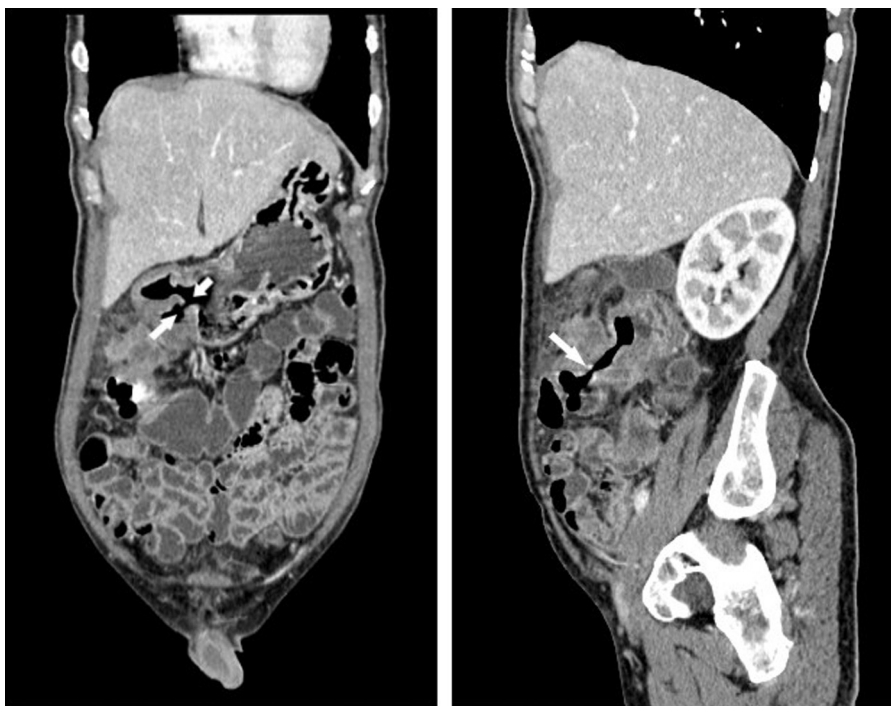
Preoperative Sagittal and Coronal CT scan revealing gastrocolic fistula demonstrated by contrast in the stomach and ascending colon.
